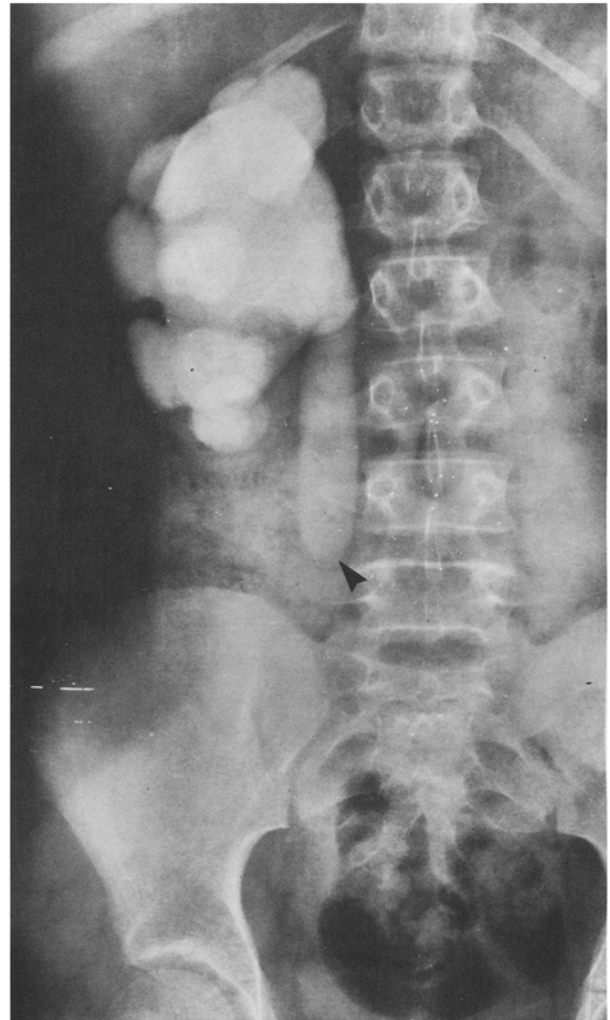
Intravenous urogram in a 12-year-old girl who presented with urinary tract infection, demonstrating midureteral obstruction (*arrow*). Exploration revealed a midureteral valve. (Reproduced with permission from Young DW, Lebowitz RL: Congenital abnormalities of the ureter. *Semin Roentgenol* 21:172, 1986.)
